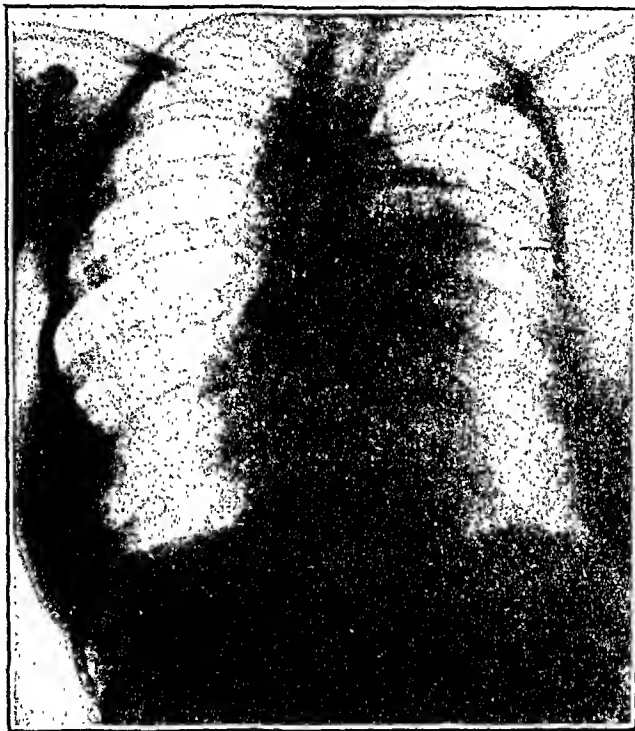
I. S., a twenty-three-year-old girl with a lifelong history of marked cyanosis of the lips and fingers and greatly diminished exercise tolerance. X-ray plate in the posteroanterior view shows the left main branch of the pulmonary artery to be markedly enlarged in its proximal portion, with visible areas of calcification. The right ventricle is markedly enlarged. Fluoroscopy confirms these findings. Diagnosis: congenital heart disease.
